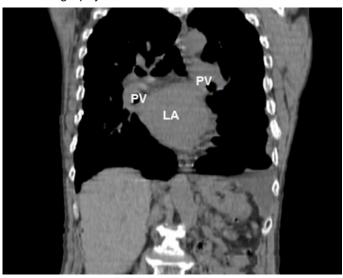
Computed tomography of the heart. Left atrium with pulmonary veins is visible on a PA view.
